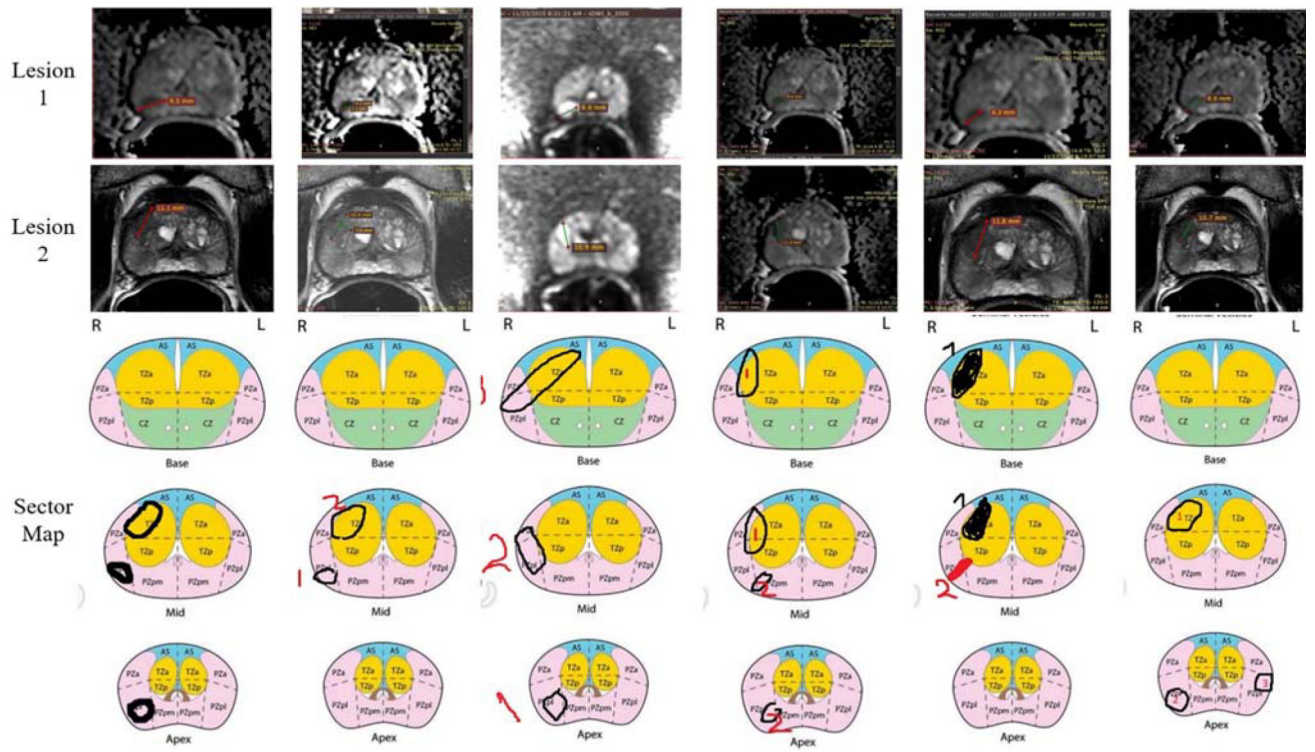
Example of interreader variability on sector map. On the top row are the screen shots of DWI images for six readers detecting the same lesion in the right mid-peripheral zone; this was the index lesion. On the second row are screen shots for all six readers detecting a lesion in the right mid-transition zone. The sector maps demonstrate the variability in how these two lesions were mapped. Both lesions were Gleason = 3+4 at prostatectomy.
